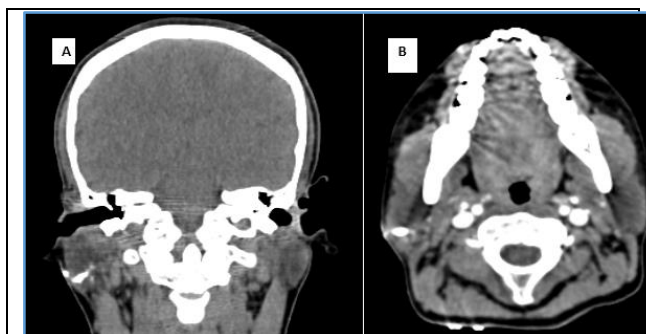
Post-Operative Patient with Intraparotid Sinus Tract: CT Sinogram (A) Coronal and (B) Axial Plane Show Intraparotid Sinus Tract in Right Parotid Gland in Coronal and Axial Images
